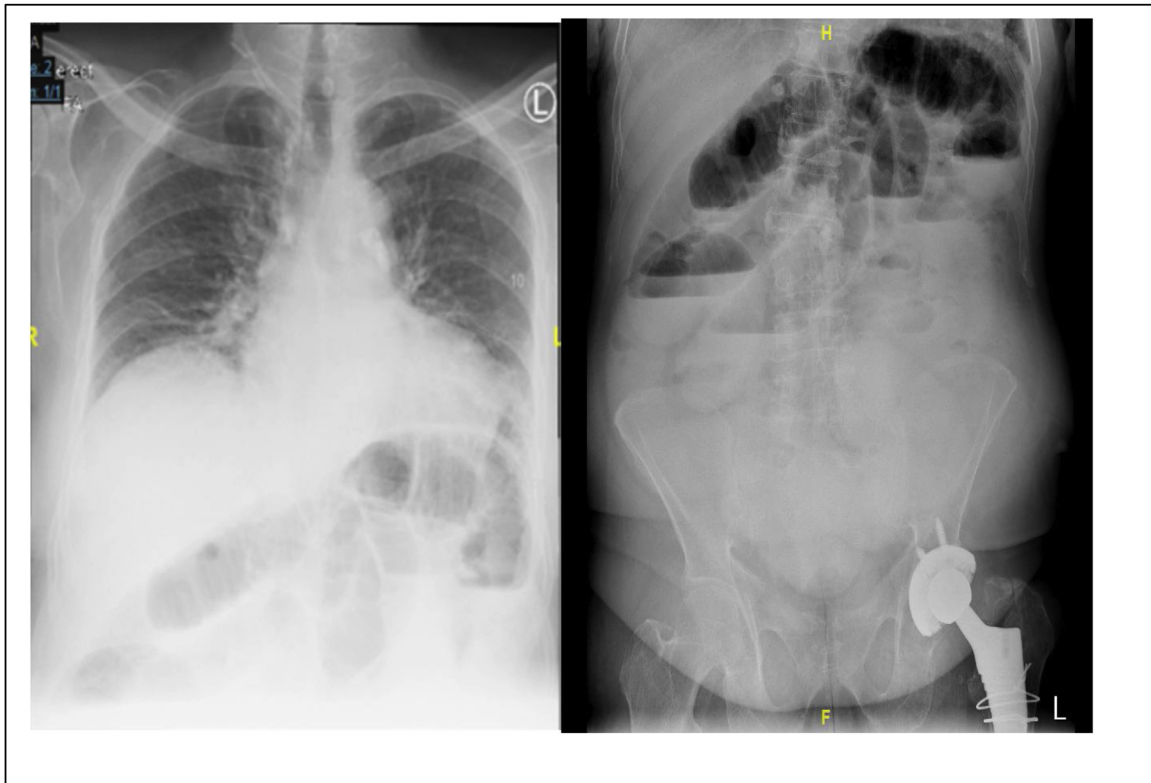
Chest and abdomen radiographs reveal dilated bowel and multiple air–fluid levels; there is no air under the diaphragm.
